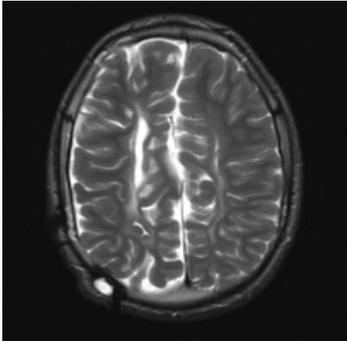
T2 MRI sequence of focal PVL.
